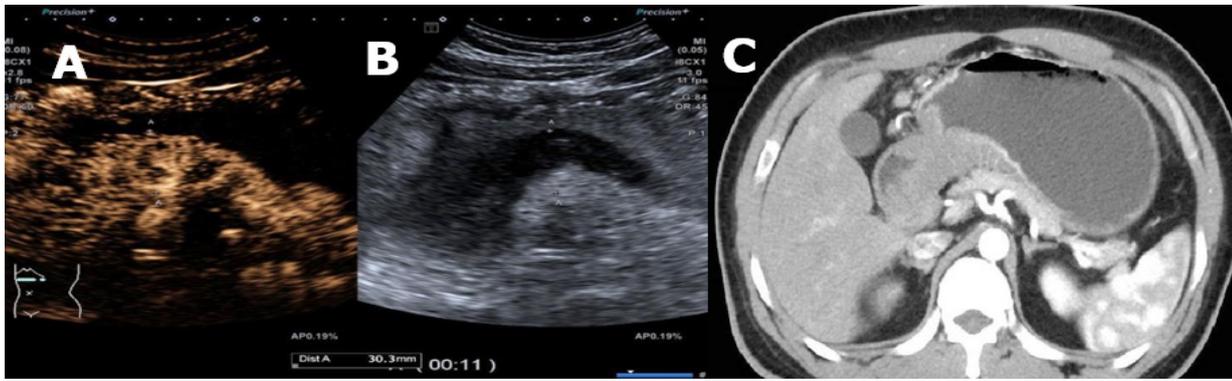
Gastric cancer in a 36-year-old man. It was confirmed as stage T4 pathologically, and staged as T4 by DCEUS and CECT. (A,B). DCEUS showed the diffuse thickened wall of the gastric antrum and invaded into the surrounding fatty tissue (Fig B arrows). The arterial phase of the lesion showed inhomogeneous enhancement, and the area of the enhanced lesion is significantly larger than the area of the lesion shown by gray-scale ultrasound (Figure A arrows). (C). CECT showed the diffuse thickened wall of the gastric antrum and invasion into the surrounding fatty tissue, with significant enhancement in the arterial phase (arrows).
